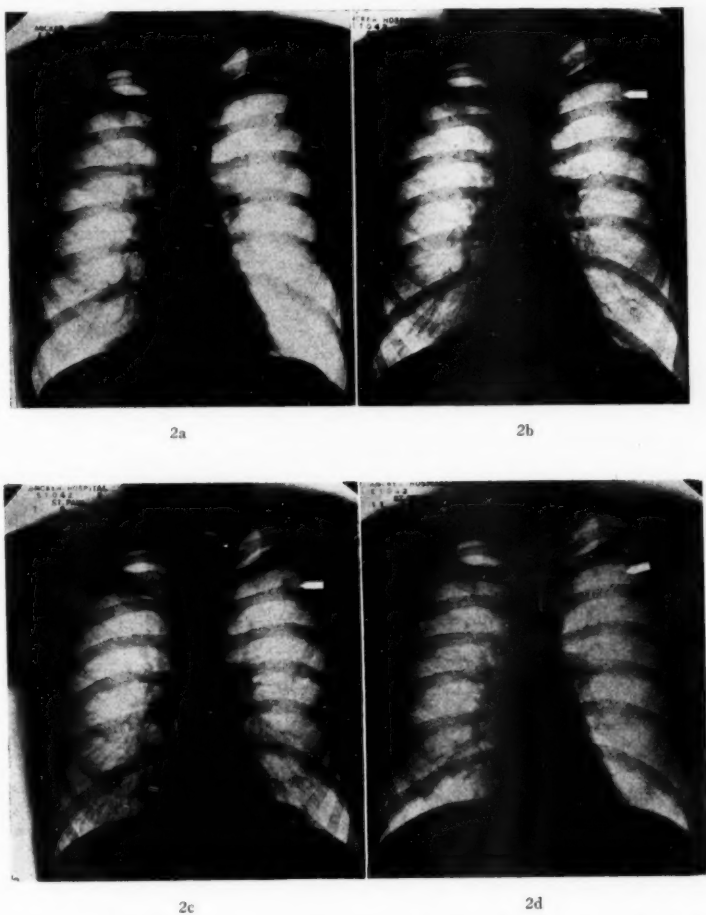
Dr. M. D. a, August, 1934—Chest radiograph shows no abnormalities. b, June, 1935—Small lesion in the left first interspace. c, July, 1935—Increase in the left upper lesion three weeks later. d, November, 1935—After four months' rest. Resolution of lesion in the left upper lobe.
